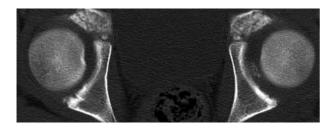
CT scan showing bony interposition preventing concentric reduction.
